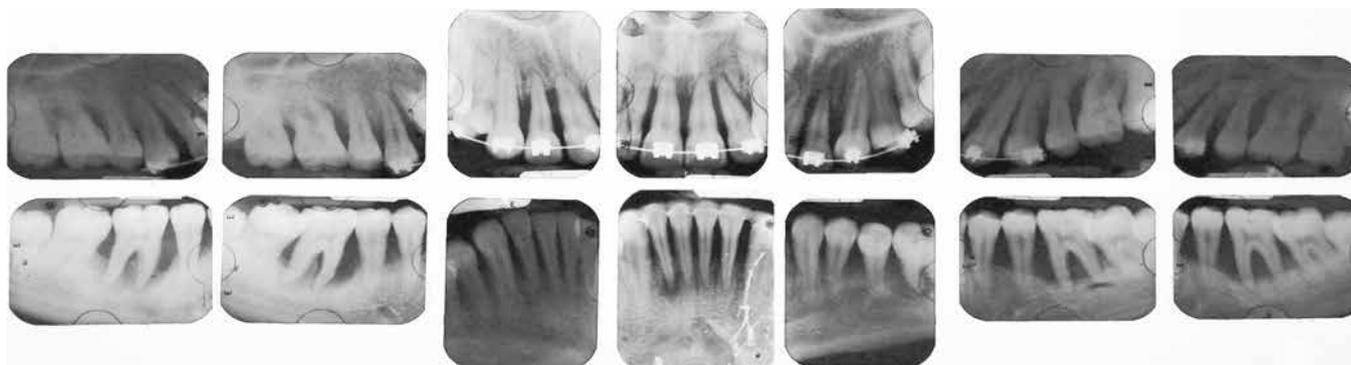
Comprehensive initial x-ray series revealing generalized severe bone loss.
